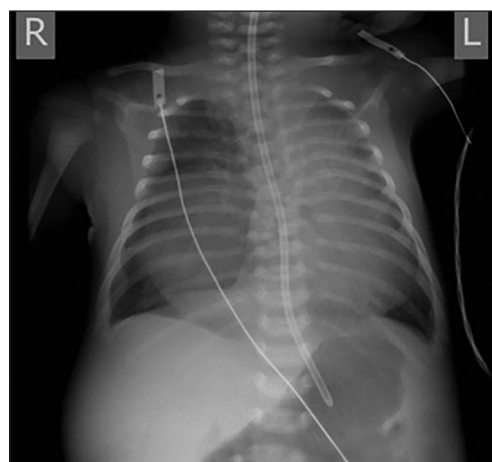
Chest X-ray taken at initial presentation—showing mass in right hemi-thorax causing mediastinal displacement. Thoracic vertebral anomalies can also be identified
